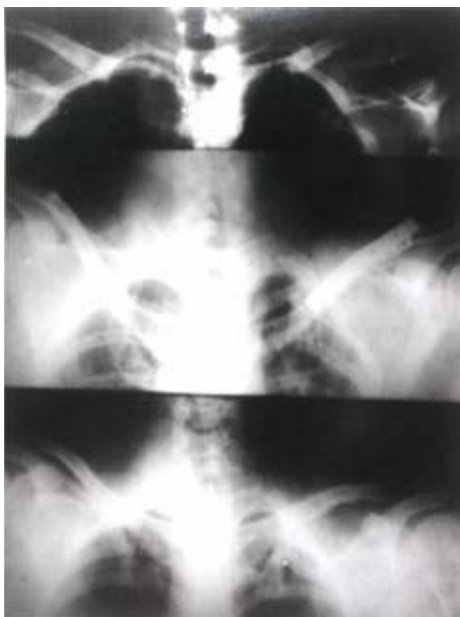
The roentgenograms of a 44-year patient with a middle clavicular non-union who was treated with DCP. The roentgenograms were obtained preoperatively, in the postoperative 6th year, and after removal of the implant.
